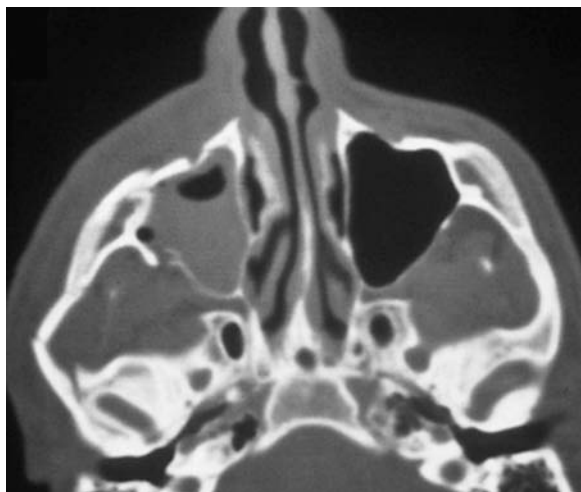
Coronal CT demonstrating the medial displacement of the right condyle.
